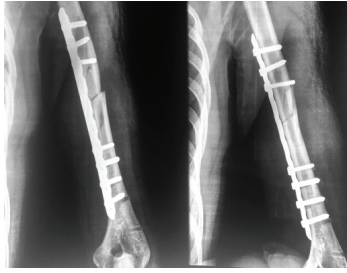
Post-operative follow-up X-ray
